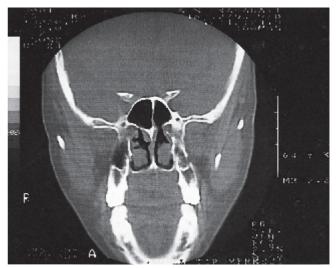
Coronal CT scan of the patient from Figures 6-7, one month post-operatively.
